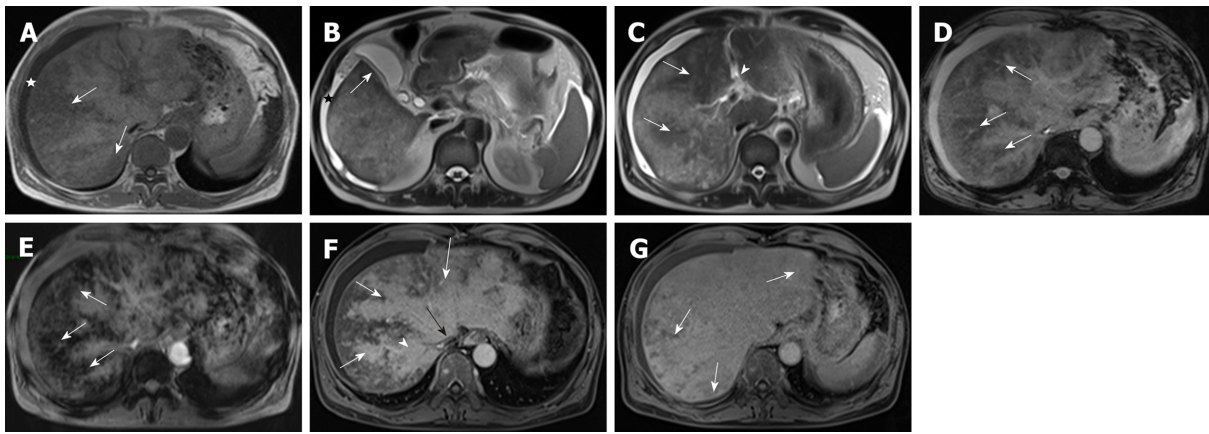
A 53-year-old man with pyrrolizidine alkaloids-induced hepatic sinusoidal obstruction syndrome (same patient) received gadoxetic acid-enhanced magnetic resonance imaging scan. A: T1-weighted imaging. Ascites (white star), heterogeneous hypointensity (white arrow) were shown; B and C: T2-weighted imaging. Imaging findings included ascites (black star, B), gallbladder wall thickening (white arrow, B), periportal edema (arrowhead, C), heterogeneous hypointensity (white arrow, C); D and E: T2*WI (D) and SWI (E). Heterogeneous hypointensity (white arrow) was observed, and distribution of hypointensity in SWI and T2*WI was similar; F: Image of portal venous phase. Patchy liver enhancement, "claw-shaped" enhancement surrounding hepatic veins (white arrow), stenosis of right hepatic vein (arrowhead) and inferior vena cava (black arrow); G: Image of hepatobiliary phase. Heterogeneous hypointensity (white arrow) was shown. SWI: Susceptibility-weighted imaging; T2*WI: T2*-weighted imaging.
